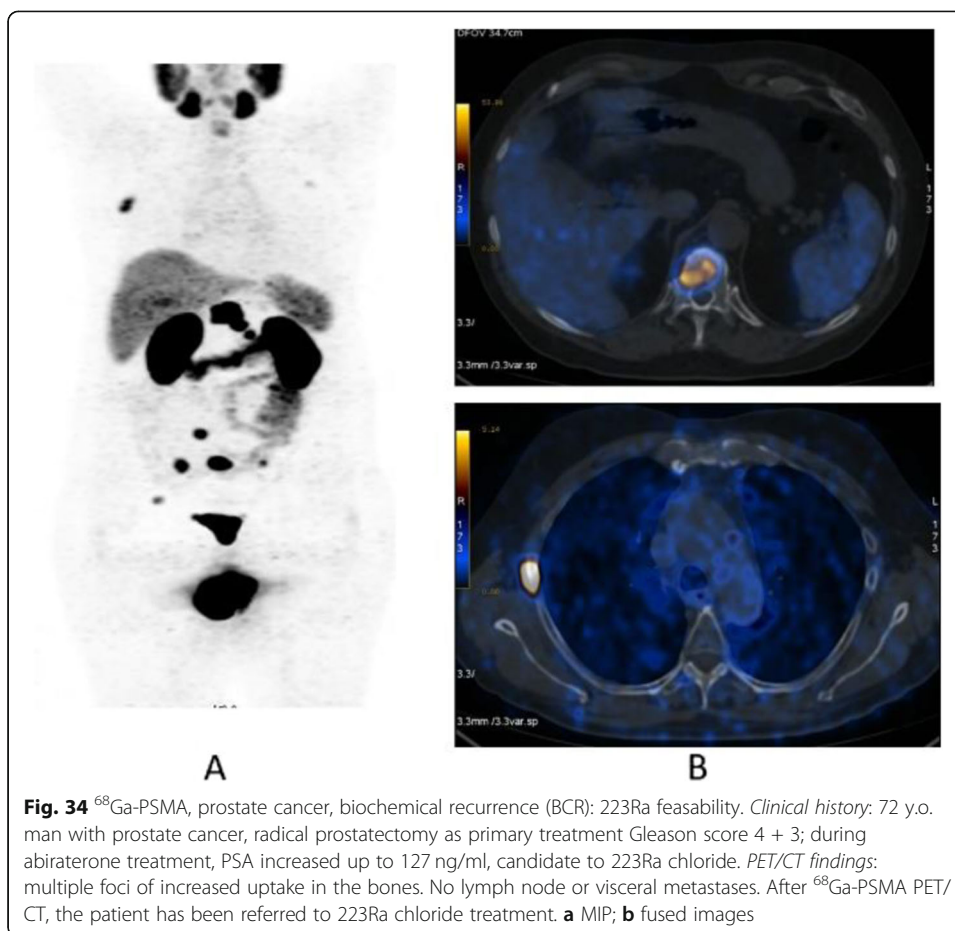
^{68}Ga -PSMA, prostate cancer, biochemical recurrence (BCR): 223Ra feasibility. *Clinical history*: 72 y.o. man with prostate cancer, radical prostatectomy as primary treatment Gleason score 4 + 3; during abiraterone treatment, PSA increased up to 127 ng/ml, candidate to 223Ra chloride. *PET/CT findings*: multiple foci of increased uptake in the bones. No lymph node or visceral metastases. After ^{68}Ga -PSMA PET/CT, the patient has been referred to 223Ra chloride treatment. a MIP; b fused images
